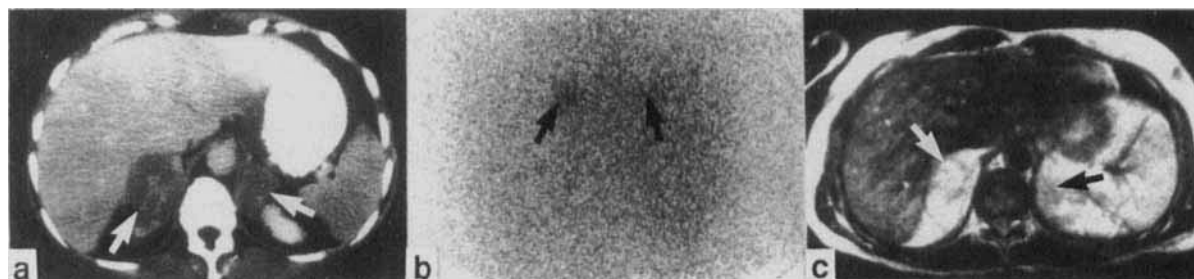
a Abdominal computed tomography (CT) scan demonstrates bilateral adrenal masses, right > left, due to lymphoma (arrows). b ^{131}I -6- β -iodomethyl-19-norcholesterol scan depicts the adrenal involvement with discernible radiotracer uptake on the left and faint uptake on the right (note the discordance with the CT scan). c T2 weighted abdominal magnetic resonance imaging (MRI) scan (at the same level as the CT scan) demonstrates the right mass (arrow) as hyperintense and the left (arrow) as more isointense as compared with the MRI signal of the liver
